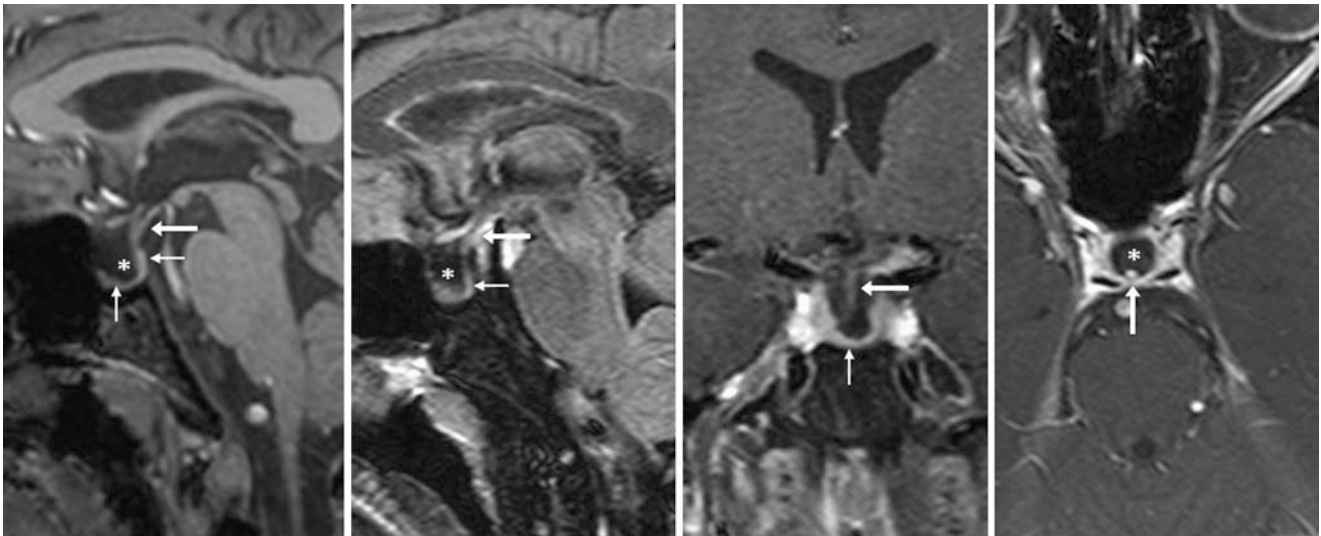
A 57-year-old female patient had vision loss (from glaucoma) and an otherwise negative 3 T MRI but a partial PES (*). Note a normal stalk (arrows) on sagittal T1WI (left) that was mildly bright on
